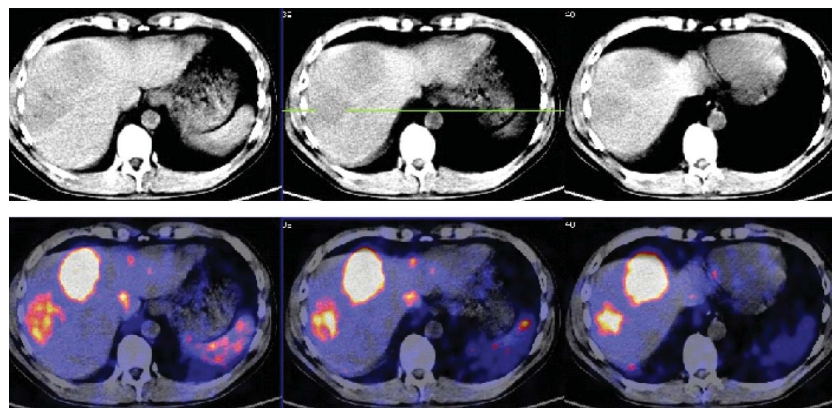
PET/CT imaging of somatostatin receptor positive liver metastases 18 h after administration of 37 MBq of ^{44}Sc -DOTA-TOC (first in human use).
